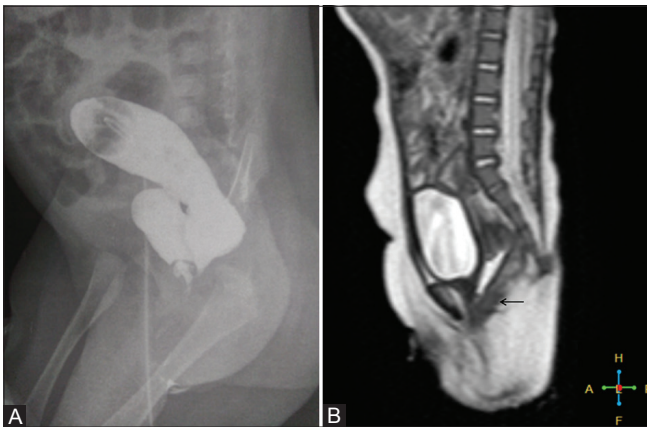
(A and B): 2-month-old female with single perineal opening at birth. (A) Distal cologram (DC) shows rectovaginal fistula. (B) T2-weighted sagittal MRI image shows convergence of rectal pouch, vagina and urethra (arrow), clearly depicting cloacal anatomy
